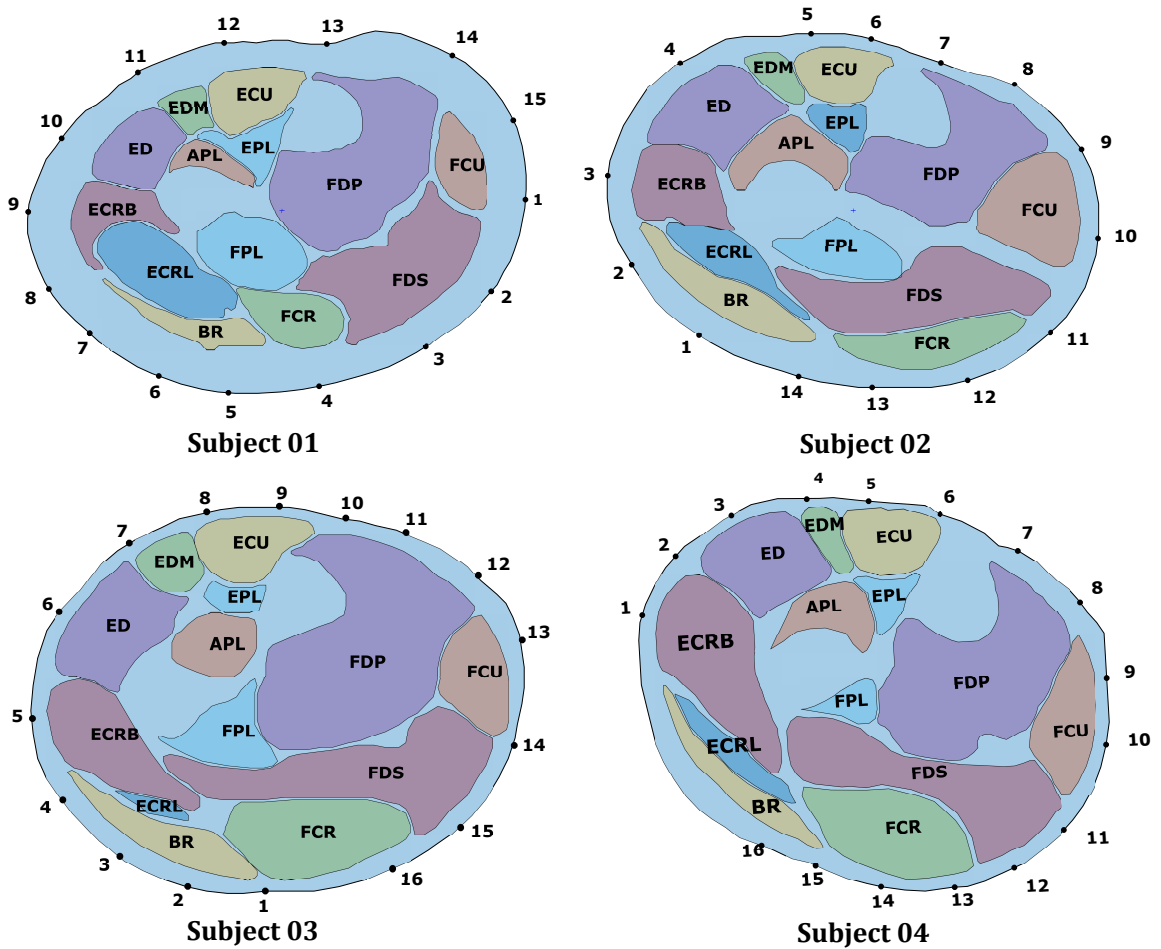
Results of the segmentation on muscles and registration of electrodes position on the 2D image plane of the MRI slice. In each MRI slice the following muscles can be identified : Abductor Pollicis Longus (APL), Extensor Pollicis Longus (EPL), Brachioradialis (BR), Extensor Digitorum (ED), Extensor Carpi Radialis Longus (ECRL), Extensor Carpi Radialis Brevis (ECRB), Extensor Carpi Ulnaris (ECU), Extensor Digiti Minimi (EDM), Flexor Digitorum Profundus (FDP), Flexor Digitorum Superficialis (FDS), Flexor Carpi Ulnaris (FCU), Flexor Carpi Radialis (FCR)
